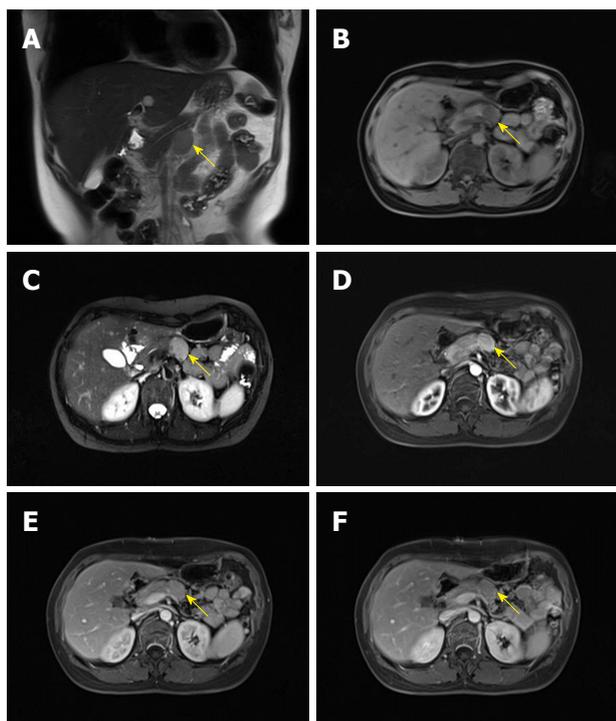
Magnetic resonance imaging of the lesion (yellow arrow) in Case 1. A: Coronal T2-weighted image sequence; B: Transverse T1-weighted fat-suppression sequence; C: Transverse T2-weighted fat-suppression sequence; D: Transverse T1-weighted fat-suppression sequence (early arterial phase); E: Transverse T1-weighted fat-suppression sequence (late arterial phase); F: Transverse T1-weighted fat-suppression sequence (delayed phase).
